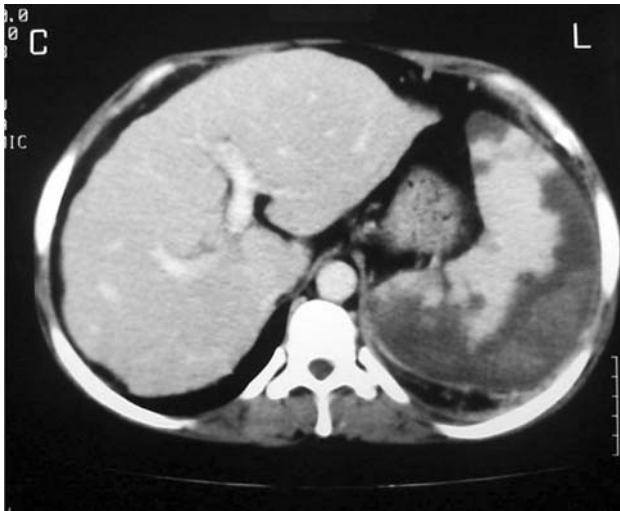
CT scan of the abdomen with intravenous and oral contrast after PSE shows the areas of splenic infarction
